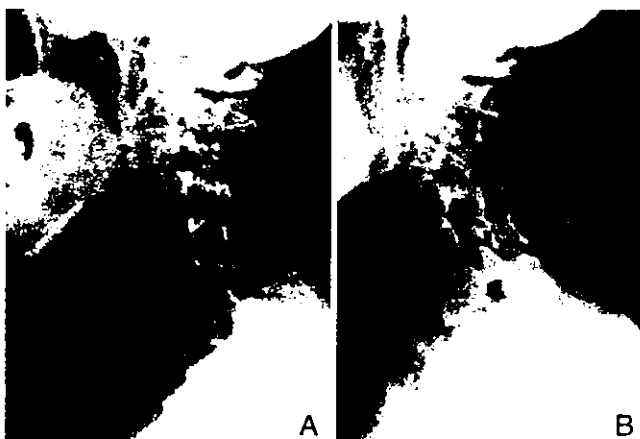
Lateral radiographs obtained in a 55-year-old woman with nonmutilating-type RA. A: Preoperative radiograph revealing subaxial lesions, such as vertebral slippage at C3–4, facet joint erosion, endplate erosion, and spinous process erosion. Vertical subluxation was stabilized. B: Five years after laminoplasty, deterioration of vertebral slippage was not found. Neurological impairment had improved from Ranawat Class IIIA to Class II.
